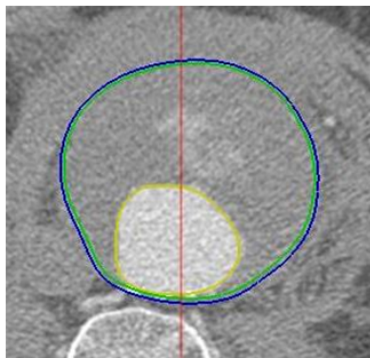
The CT scan of AAA with highlighted reconstructed geometry of it.
